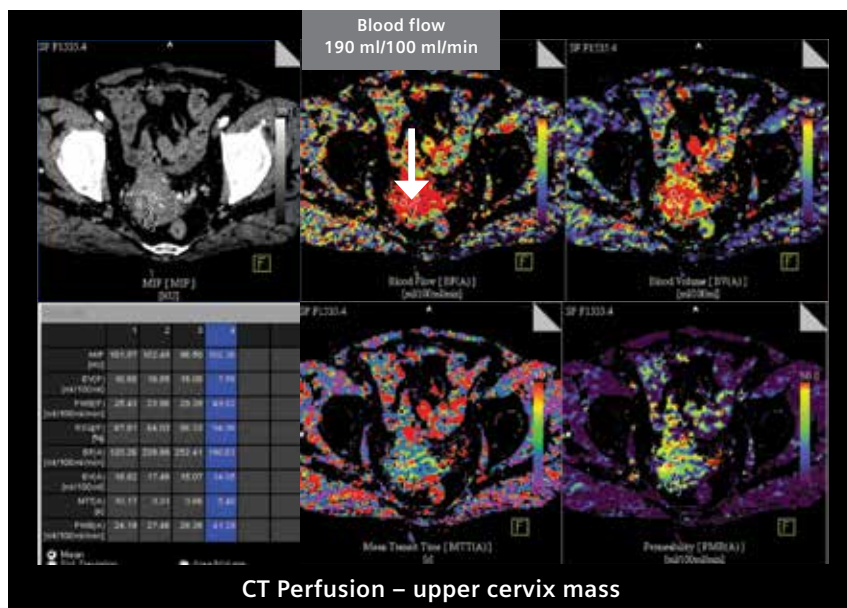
CT perfusion parametric maps show high tumor blood flow, with the highest flow of 190 ml/100 ml/min (ROI 2, white arrow).
